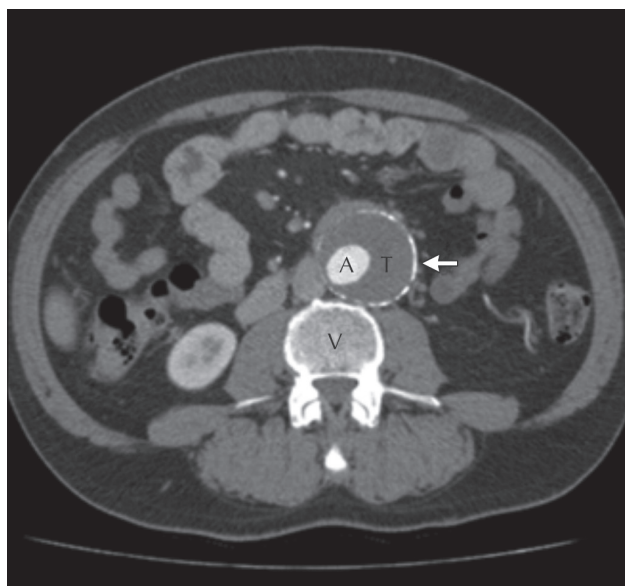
Transverse view of the abdominal computed tomography scan with contrast showing a 5.1-cm abdominal aortic aneurysm with calcification of the aneurysmal wall (arrow). A circumferential thrombus has formed (T) within the aneurysmal sac adjacent to the abdominal aorta (A). A vertebral body can also be seen (V).
